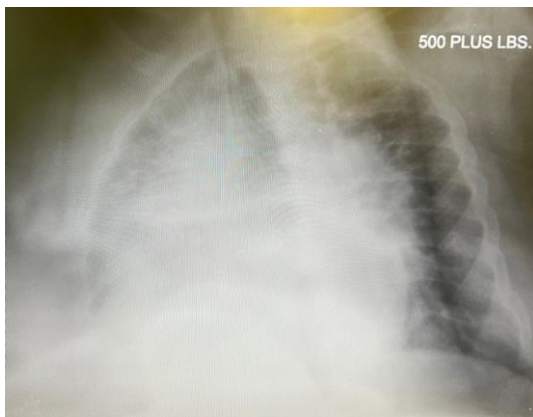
Initial Chest X-Ray of Patient During Admission
